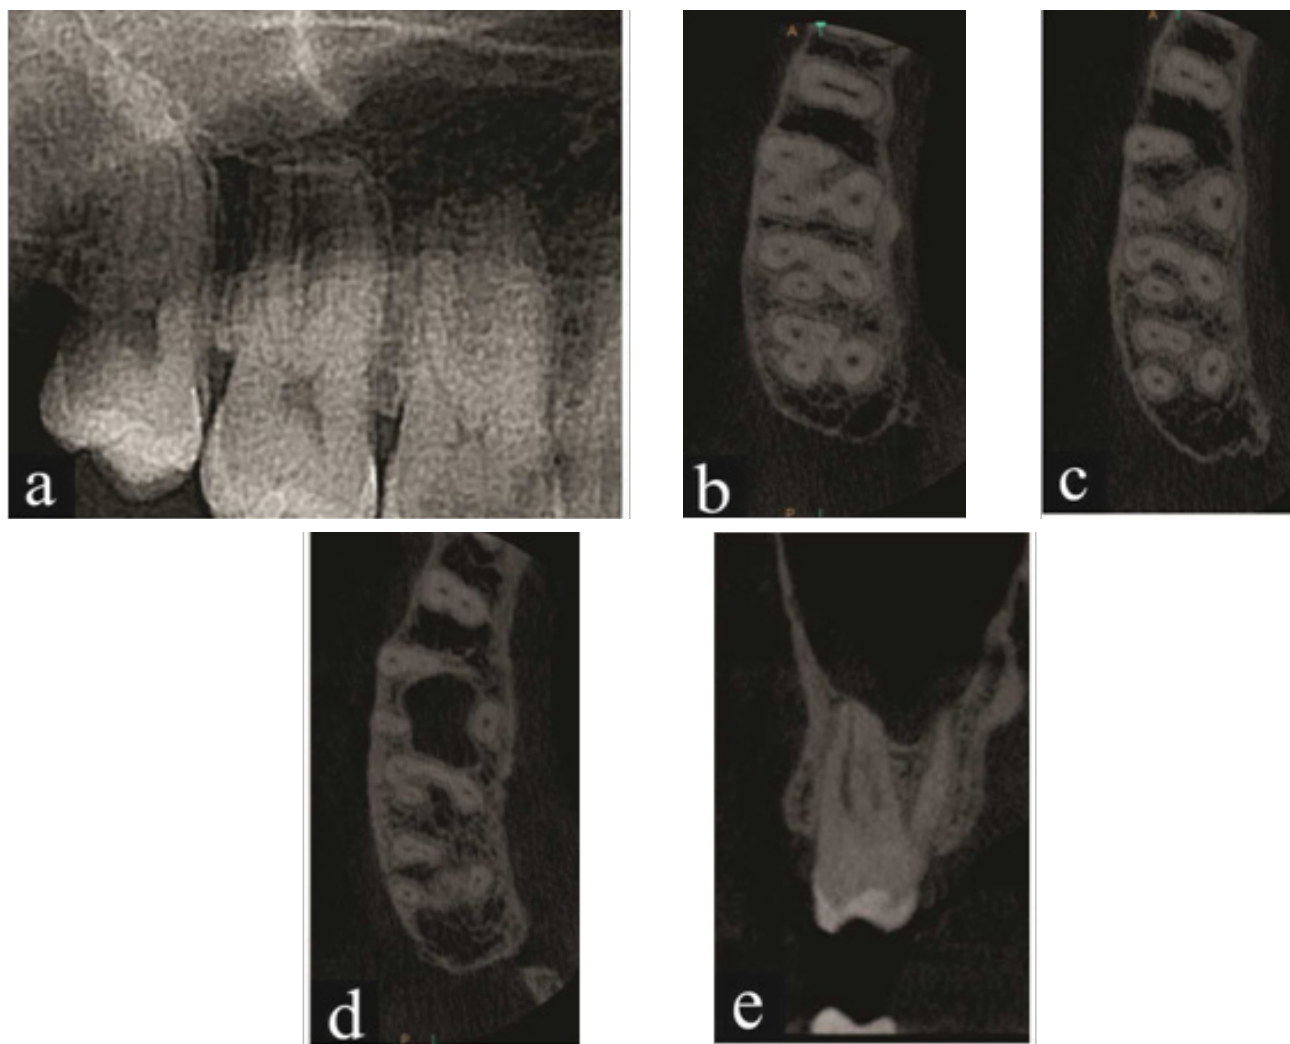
a) Preoperative radiograph; b) The limited volume CBCT axial scan at coronal third; c) The limited volume CBCT axial scan at middle third; d) The limited volume CBCT axial scan at apical third; e) The limited volume CBCT sagittal scan confirming Vertucci type IV canal configuration.
